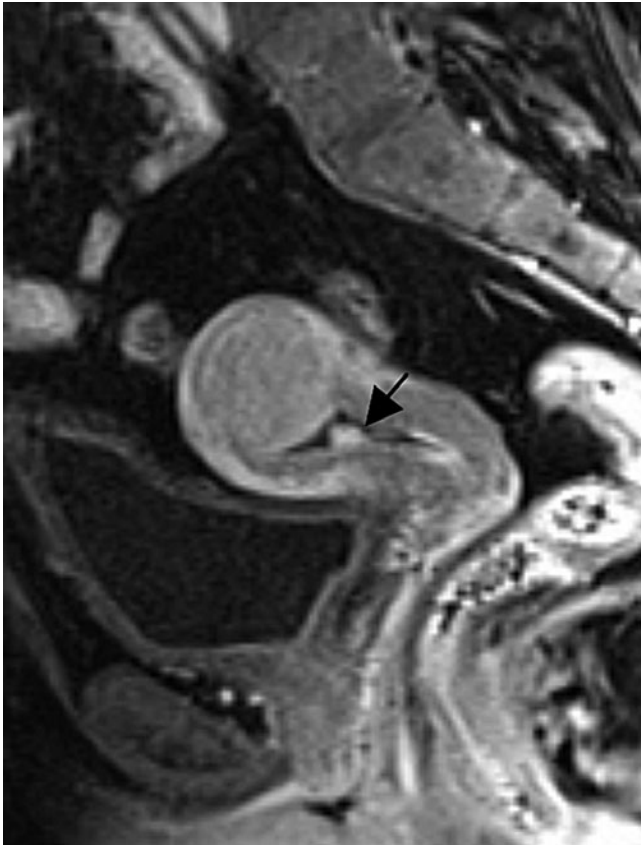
Endometrial polyp. Contrast-enhanced sagittal fat-suppressed T1-weighted magnetic resonance image (MRI) shows an enhancing lower-uterine-segment polyp (*arrow*). A fundal intramural leiomyoma with a submucosal component enhances less than the polyp
